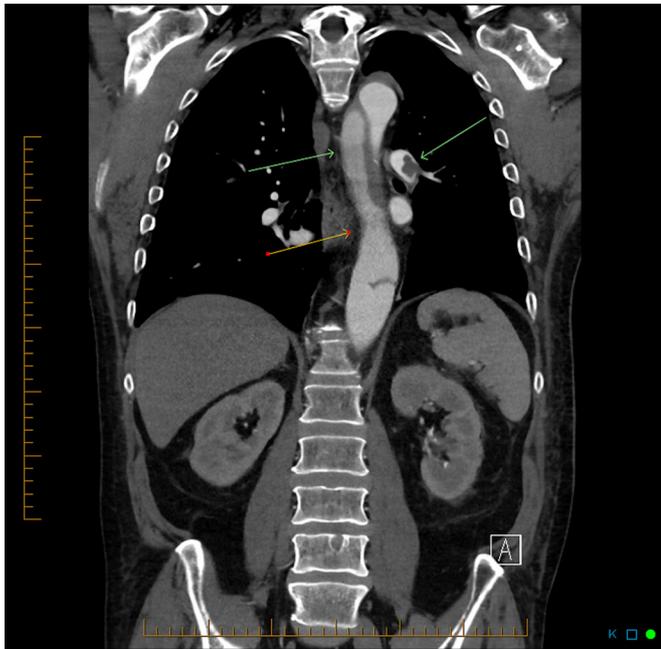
Coronal view CT image demonstrating a type B aortic dissection and large filling defect in the pulmonary trunk (as indicated by the arrows).
